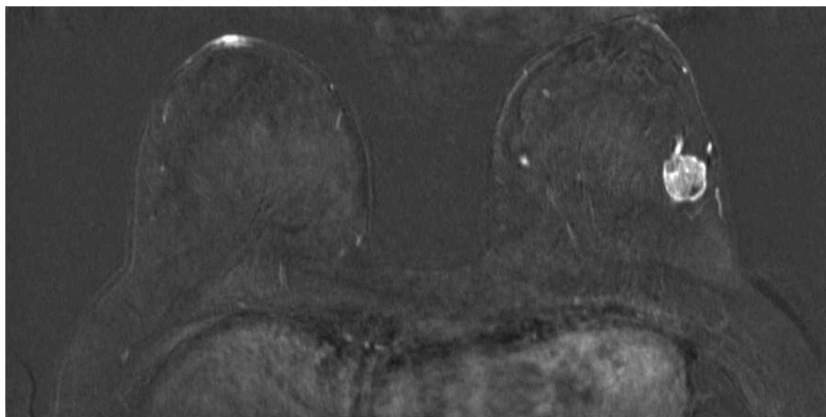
MRI features of triple negative breast cancer: regular shaped mass with rim type of enhancement.
